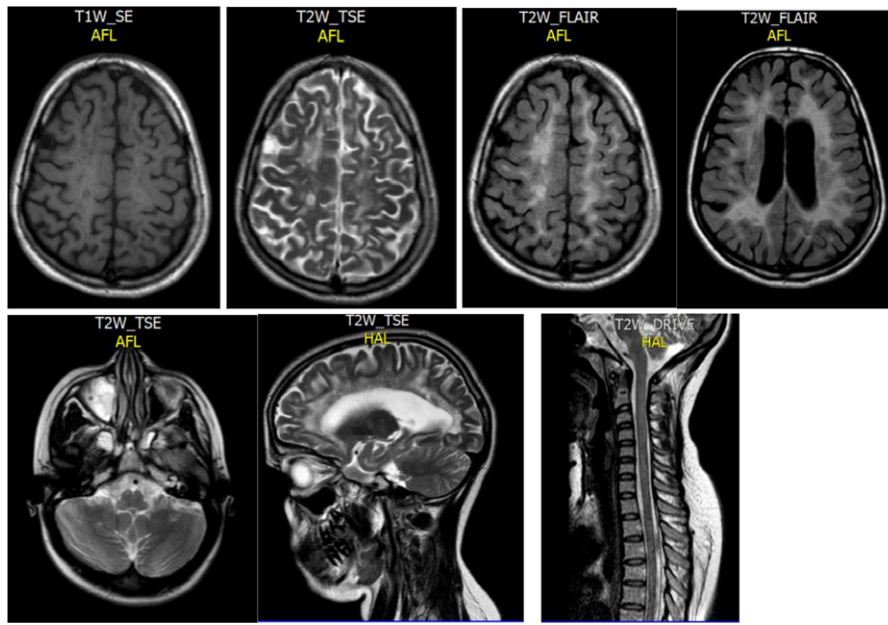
The brain MRI in December 2021 showed bilateral periventricular foci with abnormal high signal intensity on Fluid-Attenuated Inversion Recovery (FLAIR), T2-weighted Imaging (T2WI), which were hypointense on T1-weighted Imaging (T1WI), with multiple abnormal signal intensities seen in both cerebral hemispheres, pons and cerebellum; some of these lesions on post-contrast image showed incomplete ring enhancement, which is suggestive of a demyelinating process. The axial T2WI of the posterior fossa at the level of medulla oblongata showed two hyperintense signal abnormalities seen in both cerebellar hemispheres. Additionally, there was an opacification of the right maxillary sinus. Regarding the sagittal T2WI cervical and upper dorsal cord MRI, there were heterogeneous cord signals with multifocal intrinsic high signal abnormality.
